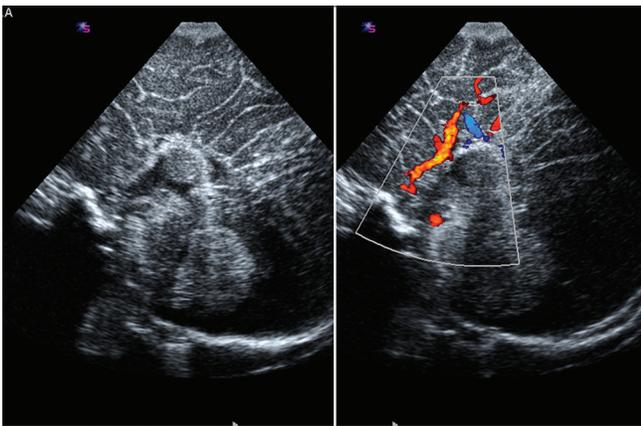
Midline sagittal gray-scale and Doppler images demonstrating agenesis of corpus callosum. Anterior cerebral artery demonstrates vertical course (sunburst appearance). Note the radiating gyri in the frontal area, characteristic of agenesis of the corpus callosum
